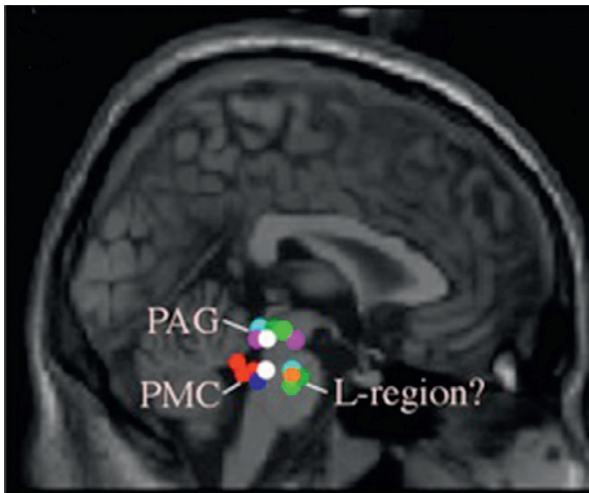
Brainstem and midbrain areas activated during withholding of urine or with a full bladder, or during voiding, projected on a sagittal section of the brain. PAG, periaqueductal gray; PMC, pontine micturition center; L-region is a putative pontine continence center. Based on positron emission tomography, functional magnetic resonance imaging, and single-photon emission computed tomography studies in healthy controls. (Adapted from Griffiths and Tadic, 2008.)
